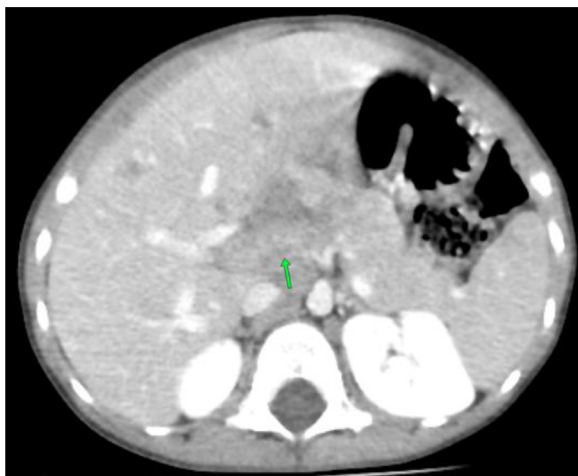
Axial contrast-enhanced abdominal CT image showing hypo enhancing periportal confluent lymphadenopathies (green arrow).
